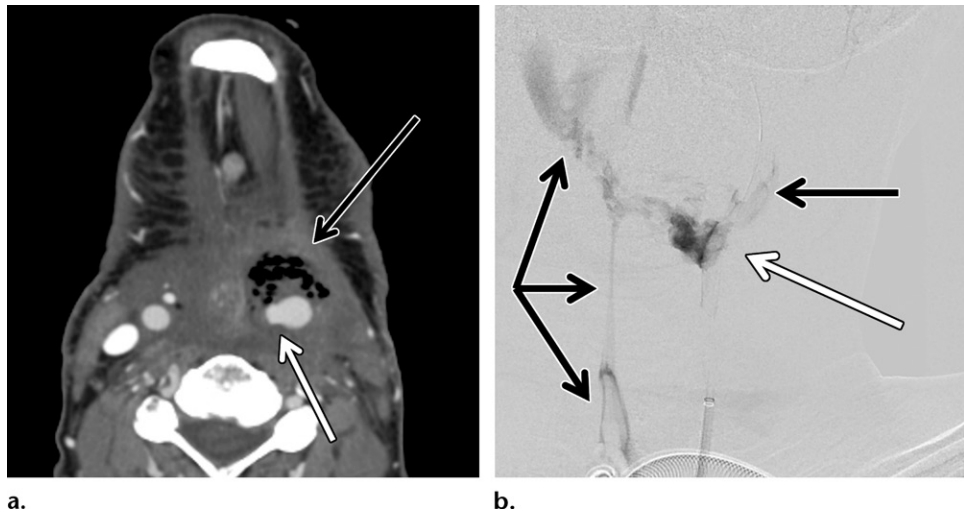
Carotid artery blowout syndrome in a 51-year-old woman with recurrent laryngeal cancer who was treated with total laryngectomy and radiation and who presented with intermittent hematemesis. (a) Axial contrast-enhanced CT image shows a peripherally enhancing necrotic mass with internal foci of air that is suggestive of ulceration and connection to the pharynx (black arrow). Involvement of the distal common carotid artery with formation of a pseudoaneurysm (white arrow) raises concern for an impending rupture with intermittent hematemesis. (b) Oblique angiogram from left common carotid artery injection shows the pseudoaneurysm in the distal left common carotid artery (white arrow), with extravasation of arterial contrast material into the pharynx (black arrows).
